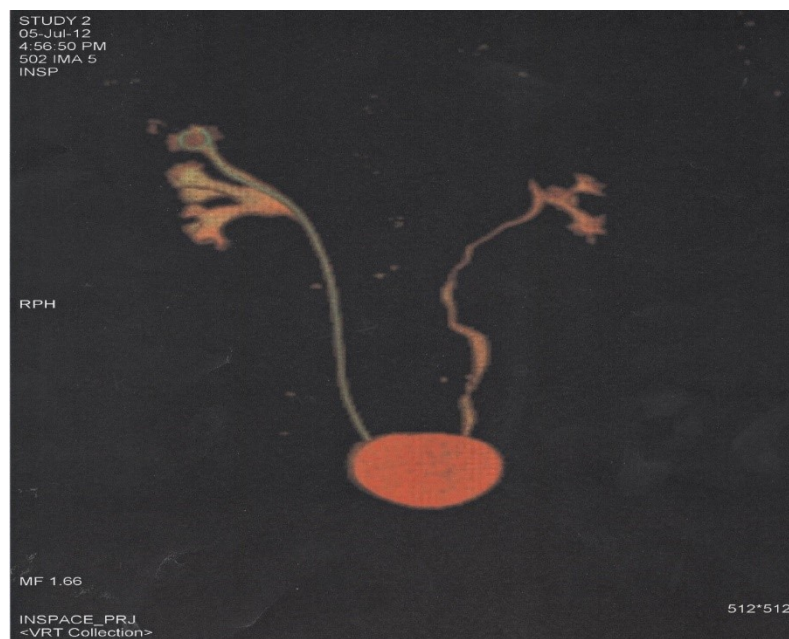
CT Urography 2012.
